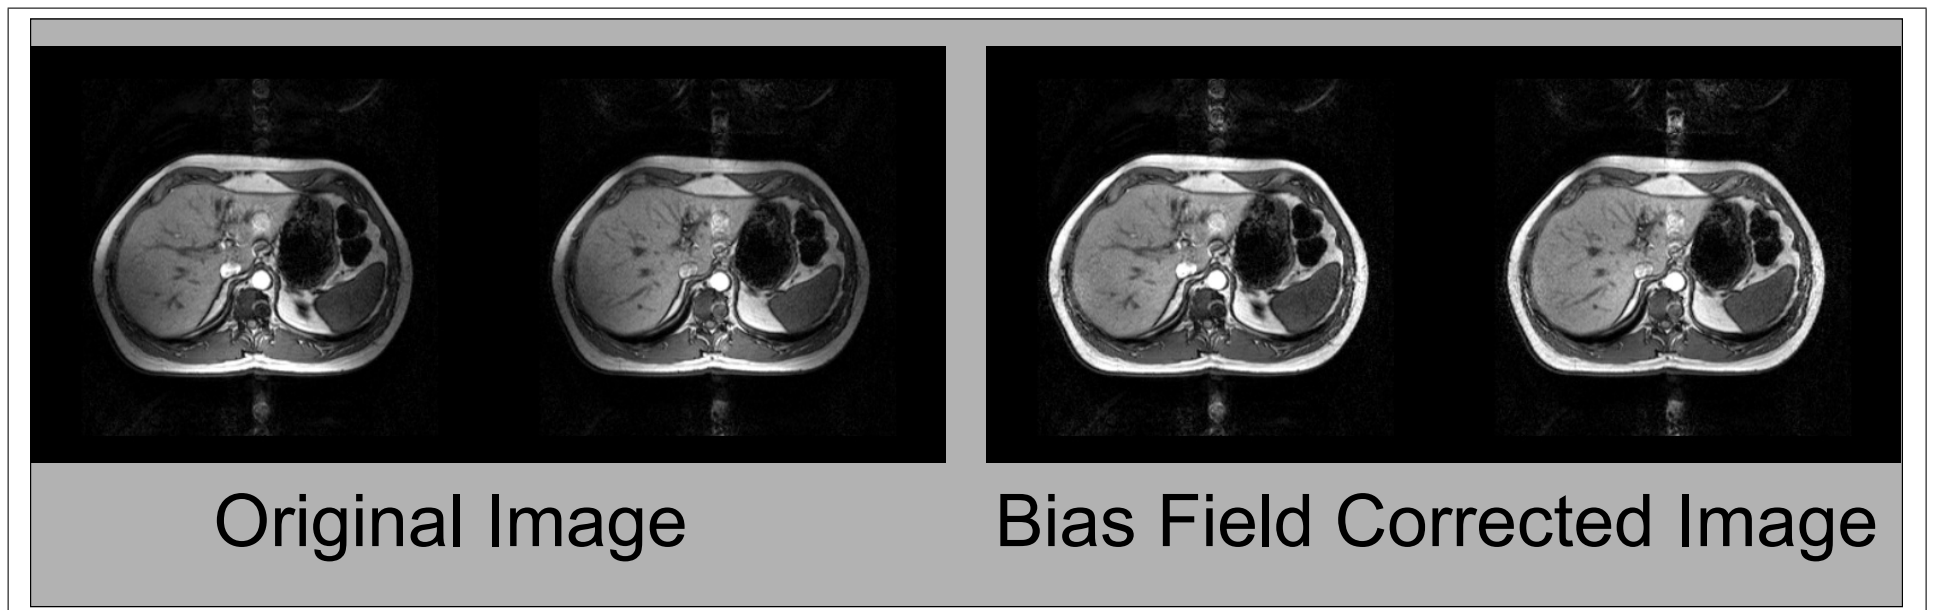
Abdominal Image Bias Field Correction. *Left:* Consecutive slices from an abdominal MRI image acquired with a parallel image sequence. Note the strong shading artifacts especially in the outer fat layer and the liver on the lower left. *Right:* Bias field corrected abdominal image exhibiting much improved contrast and fat layer homogeneity.
